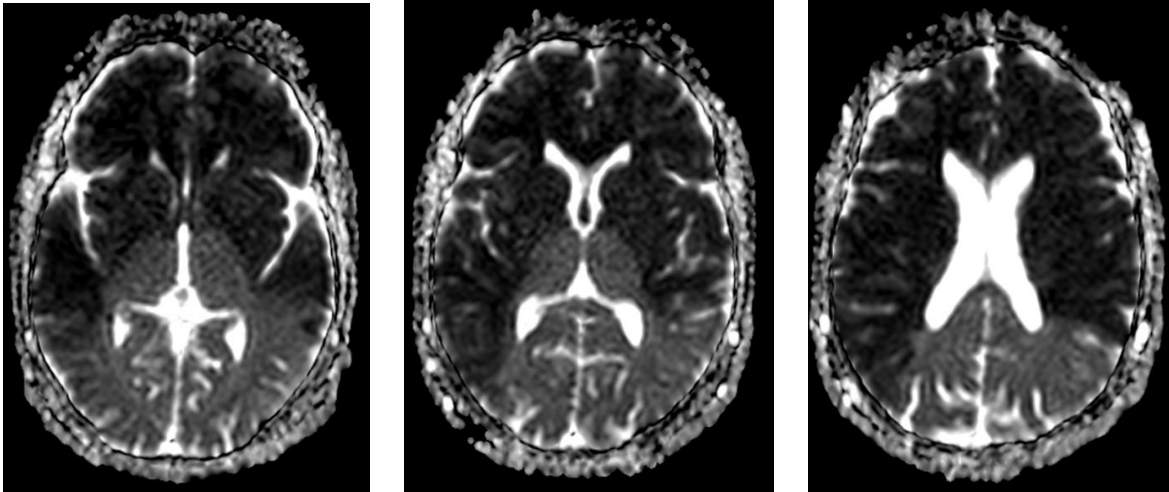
Brain MRI in axial sections: top row shows DWI sequence and bottom row shows ADC map; true diffusion restriction in the territory of the internal carotid artery is demonstrated bilaterally.
